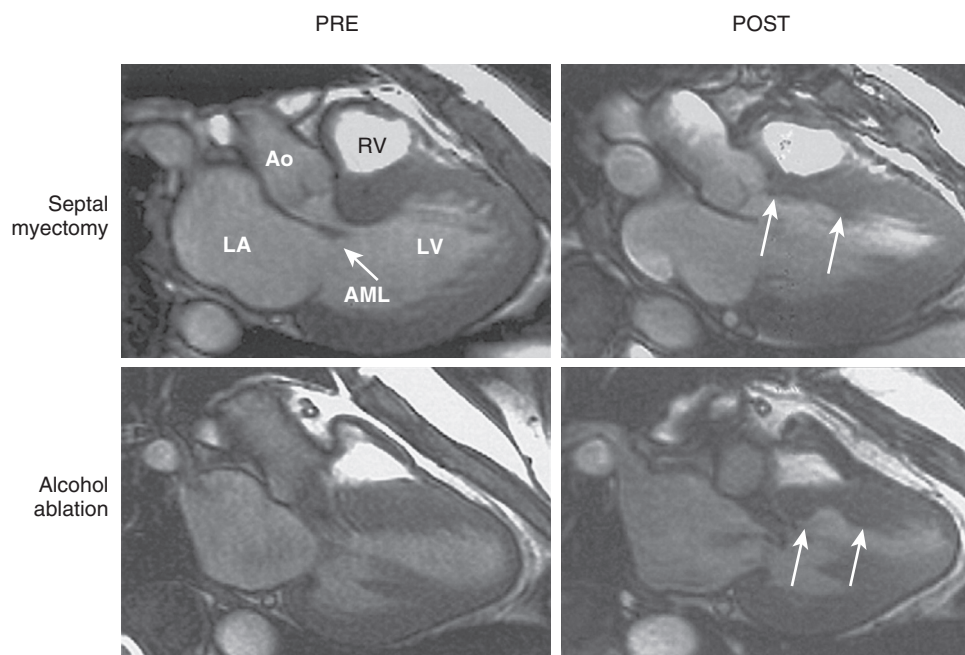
■ Cardiac magnetic resonance image after septal myectomy versus septal ablation. *Top panels*, Long-axis views before (Pre) and after (Post) septal myectomy. The portion of basal septum evident in this plane, projecting into the left ventricular (LV) outflow tract, has been excised at myectomy (arrows). *Bottom panels*, Long-axis views before (left) and 5 months after (right) septal ablation. Ablation has spared the most proximal portion of basal septum. AML, Anterior mitral leaflet; Ao, aorta; LA, left atrium; RV, right ventricle. (From Valeti US, Nishimura RA, Holmes DR, et al: Comparison of surgical septal myectomy and alcohol septal ablation with cardiac magnetic resonance imaging in patients with hypertrophic obstructive cardiomyopathy. *J Am Coll Cardiol* 49:350–357, 2007.)
